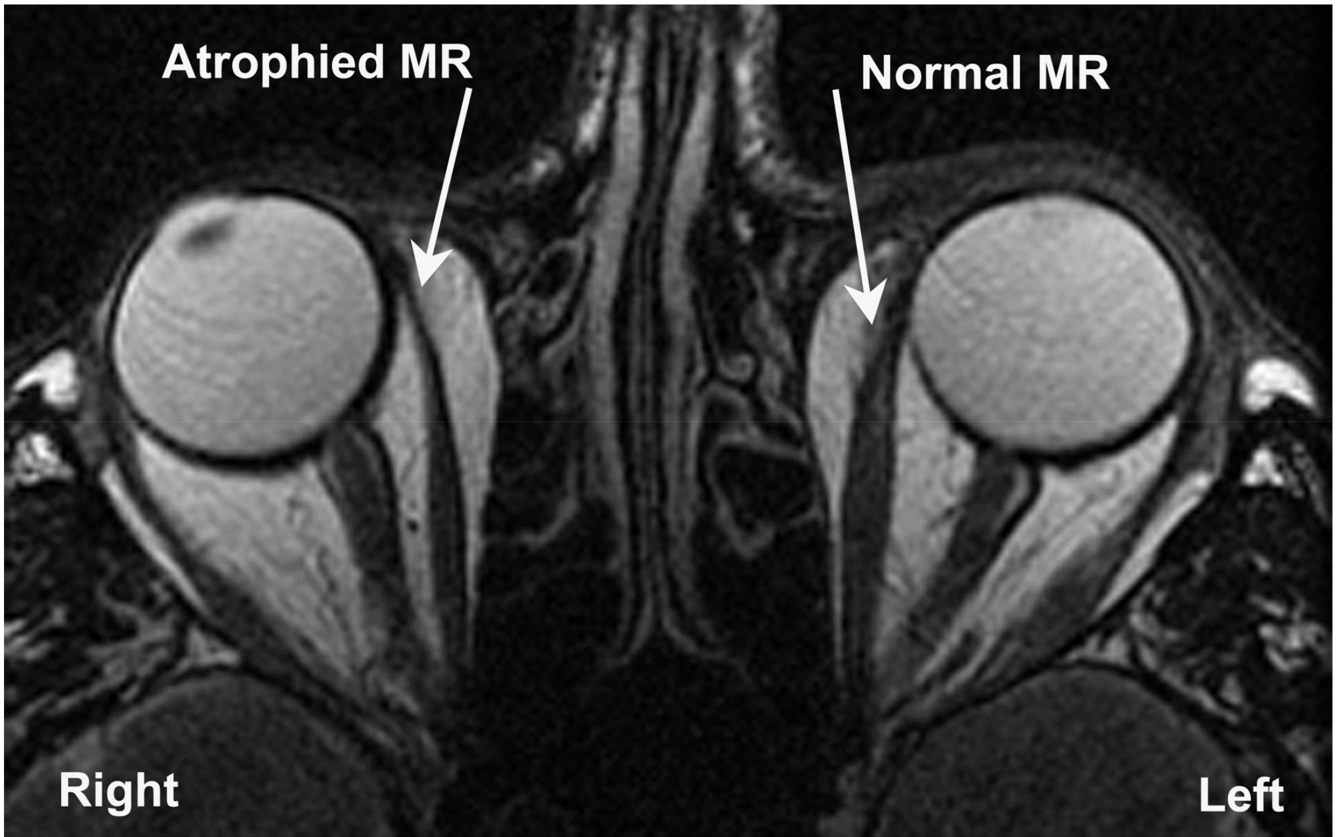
Axial T2-weighted surface coil MRI disclosing right medial rectus muscle (*MR*) atrophy in case 1.
